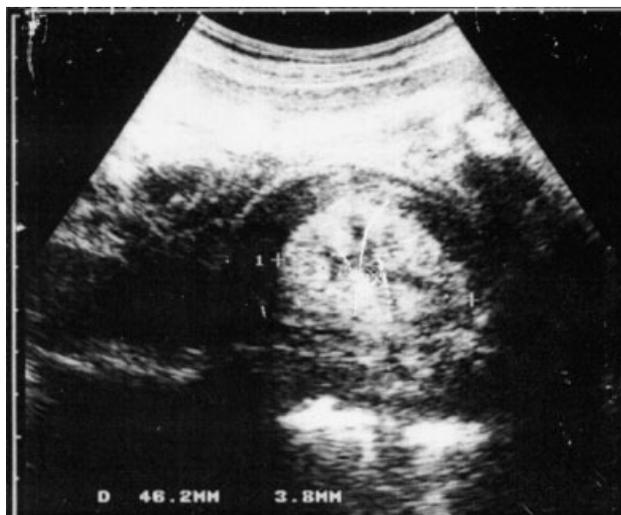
Ultrasound scan at 29 weeks' gestation showing enlarged and hyperechogenic kidneys (Case 2)
